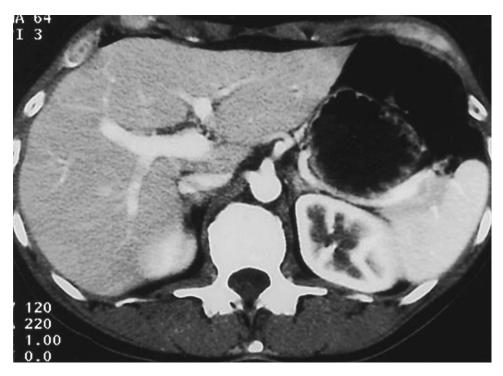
CT control performed 4 days after operation shows complete disappearance of the previously described alterations.
